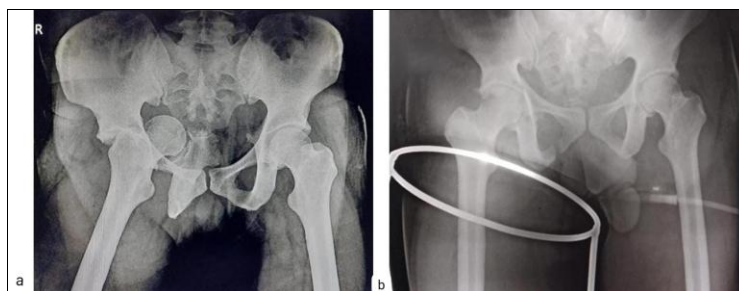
X-rays: (a) At presentation (b) After closed reduction
